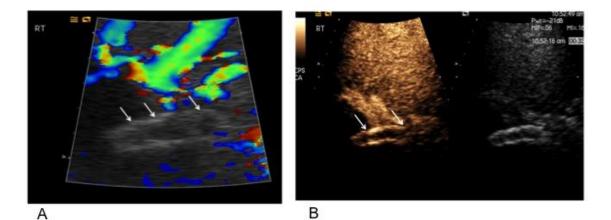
Another case of TIPSS in which optimized colour Doppler could not show any flow inside the shunt (A, arrows). CEUS examination confirms the diagnosis of thrombosis of the shunt in (B) (arrows).
